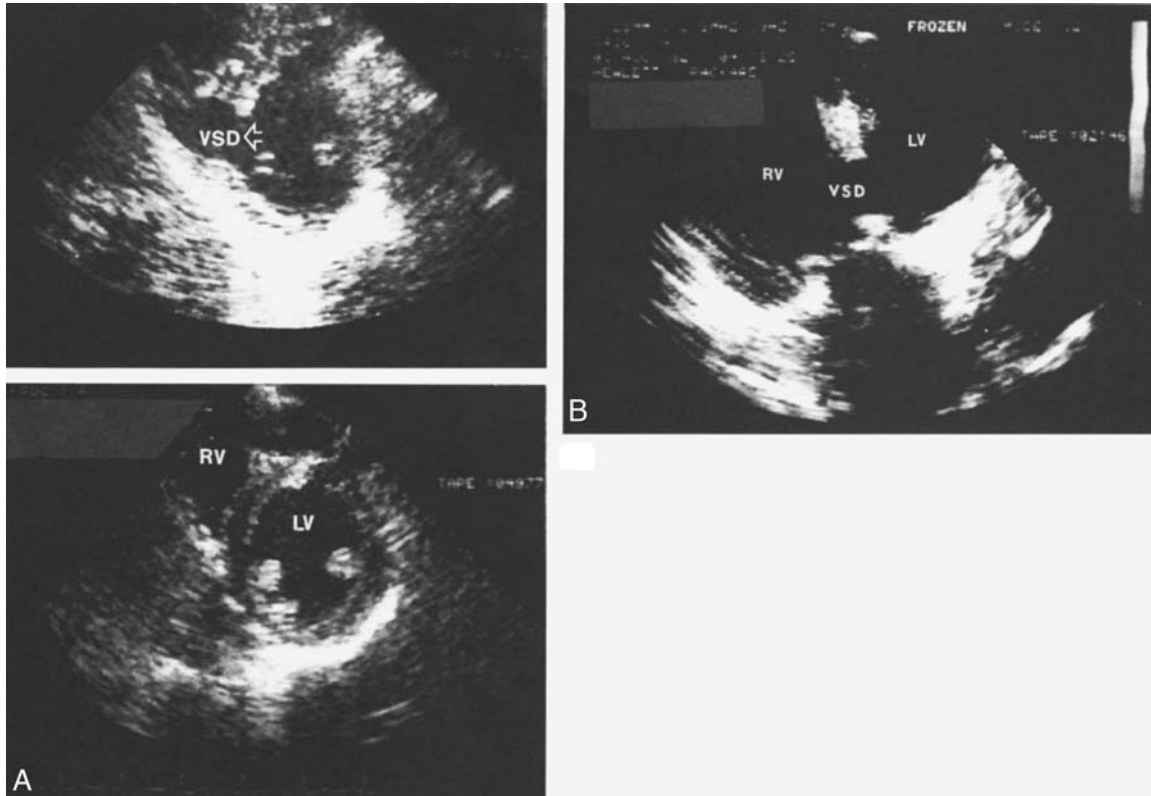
Two-dimensional images from two patients with ventricular septal defect. (A) Two parasternal short axis frames. The lower frame is through the level of the papillary muscles and at this point the interventricular septum is intact. As the beam is scanned superiorly the ventricular septal defect (VSD) is visualized. (B) A large ventricular septal defect seen in the apical four-chamber view. (From Julian, D.G., Ed., *Diseases of the Heart*, London: W.B. Saunders, 325, 1996.)
